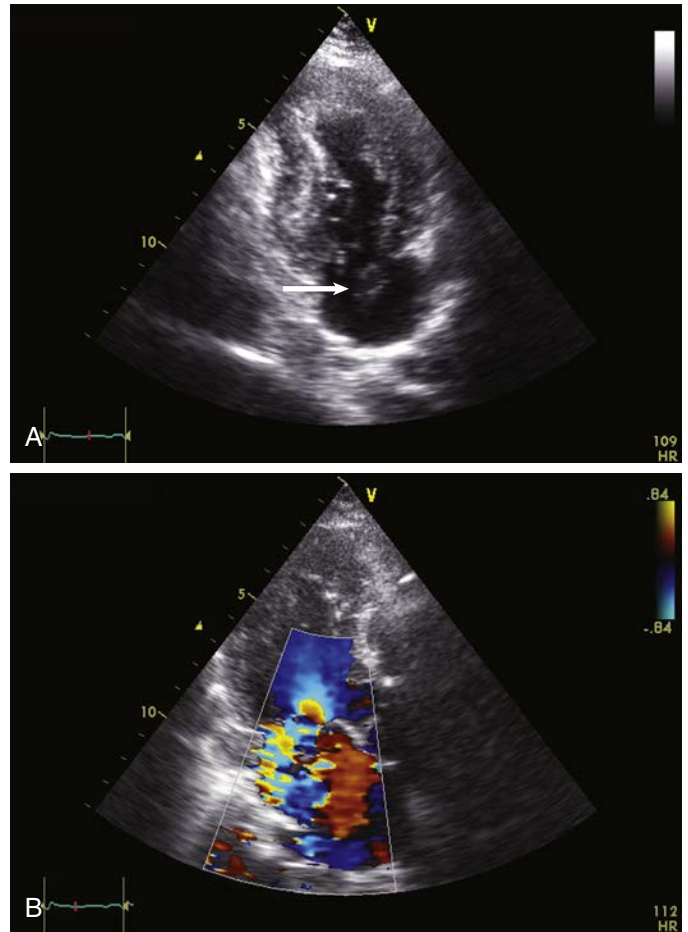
Papillary muscle rupture. Transthoracic echocardiography (TTE) in a patient in cardiogenic shock 24 hours after an anterior myocardial infarction. (A) Apical two-chamber view shows rupture of the anterolateral papillary muscle, which has moved freely into the left atrium (arrow). (B) Apical long-axis view shows severe mitral regurgitation in the same patient.
